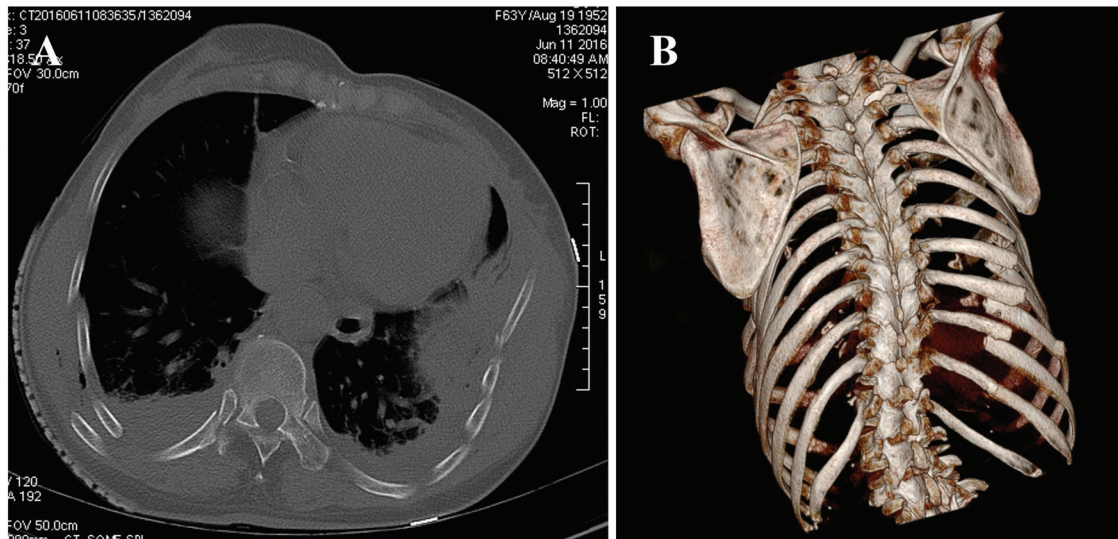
Multiple rib fractures accompanied with pulmonary contusion on chest CT. (A) transverse plane, (B) three-dimensional reconstruction. CT: computed tomography
